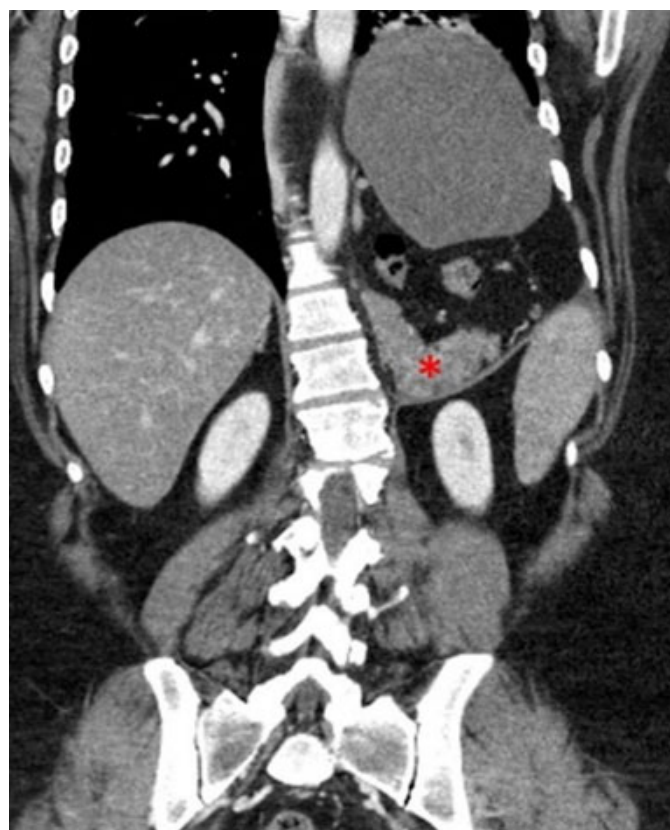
CT abdomen and pelvis with IV contrast coronal view. Herniation of pancreatic tail above the left hemidiaphragm labeled in red asterisk.
